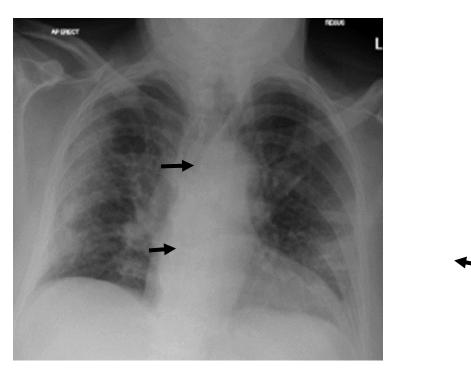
A frontal radiograph demonstrating the classic pattern of bilateral peripheral opacities (44).
